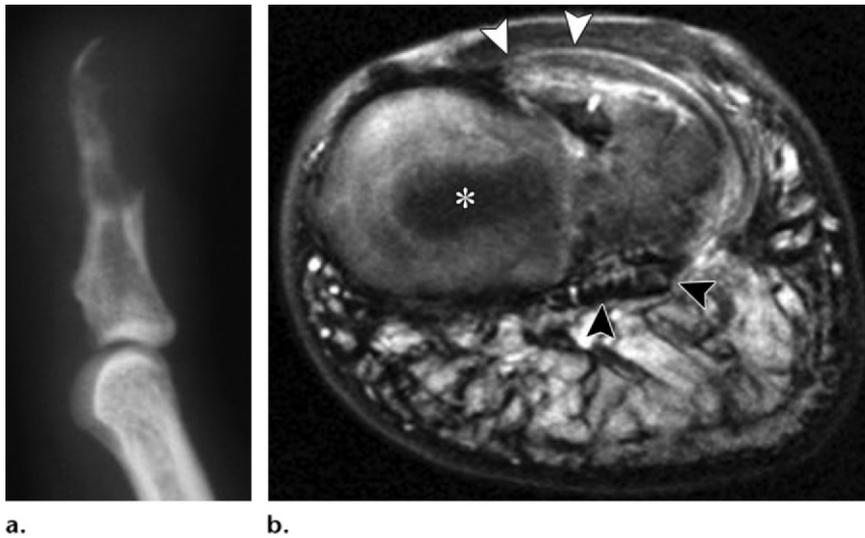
Epidermoid inclusion cyst mimicking a primary bone lesion. (a) Radiograph demonstrates a well-delineated, irregular lucent lesion of the tuft of the distal phalanx with cortical disruption. (b) Axial fat-saturated T2-weighted MR image reveals an epidermoid inclusion cyst invading the tuft (black arrowheads) and extending to the nail bed, pushing back the ungual matrix (white arrowheads). The inclusion cyst contains T2-hypointense keratin lamellae centrally (*).
